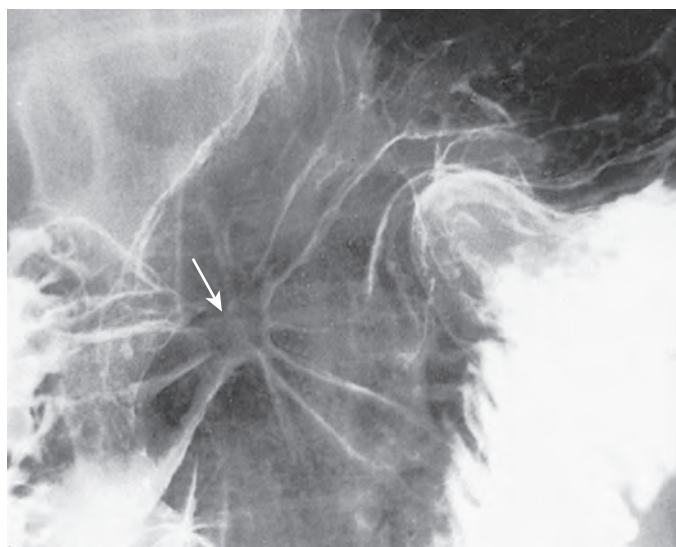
Ulcer scar with folds radiating to a central depression. Multiple folds are seen radiating to a central area (arrow) that could be mistaken for a shallow, residual ulcer crater. (From Levine MS, Creteur V, Kressel HY, et al: *Benign gastric ulcers: Diagnosis and follow-up with double-contrast radiography*. *Radiology* 164:9–13, 1987.)
